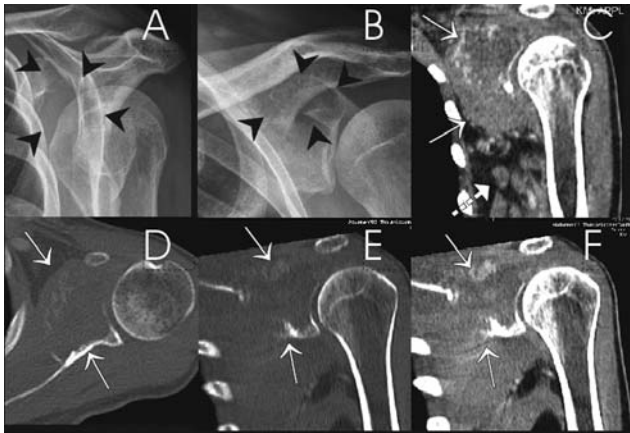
Image findings of the left shoulder in a 48-year-old man suffering from epithelioid angiosarcoma of the scapula. A, B: Plain x-ray radiography shows a large bone destruction of the glenoid appearing as homogenous radiolucent area with no calcification and no reactive bone sclerosis at the margins (arrowheads). C-F: CT-scan allows better assessment of the intraosseous extension (D, E: bone window, arrows) with partial destruction of the articular surface and the anterior border of the glenoid and adjacent scapula. Soft tissue window (C, F: arrows) exhibits the distinctive extraosseous soft tissue component extending to the axilla as well as local lymph node enlargement (C: broken arrow).
